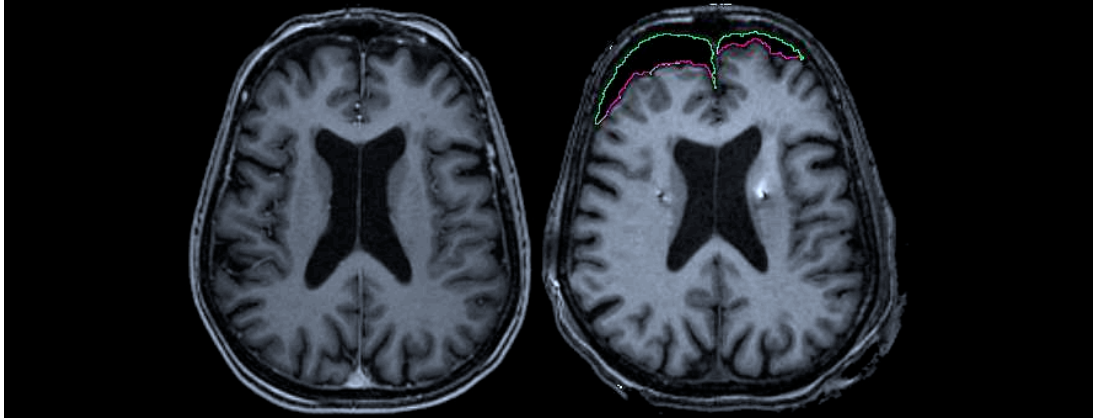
Pre-operative (left) MR image without brain shift, and post-operative (right) MRI showing asymmetric brain shift. The green and pink contours is a segmentation of the pneumocephalus (air inside skull). The pink line represents the surface of the brain in contact with air.
